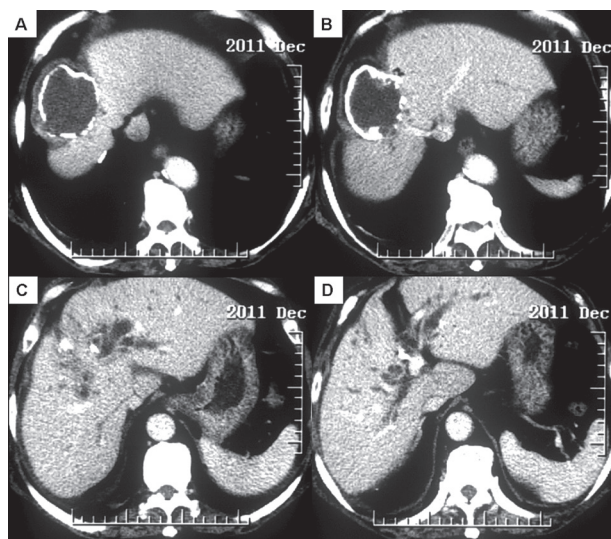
Axial computed tomography scans of the liver demonstrating a relatively large cystic lesion in the right hepatic lobe with calcification of cyst well (A-B) and intrahepatic bile duct dilation (C-D)
